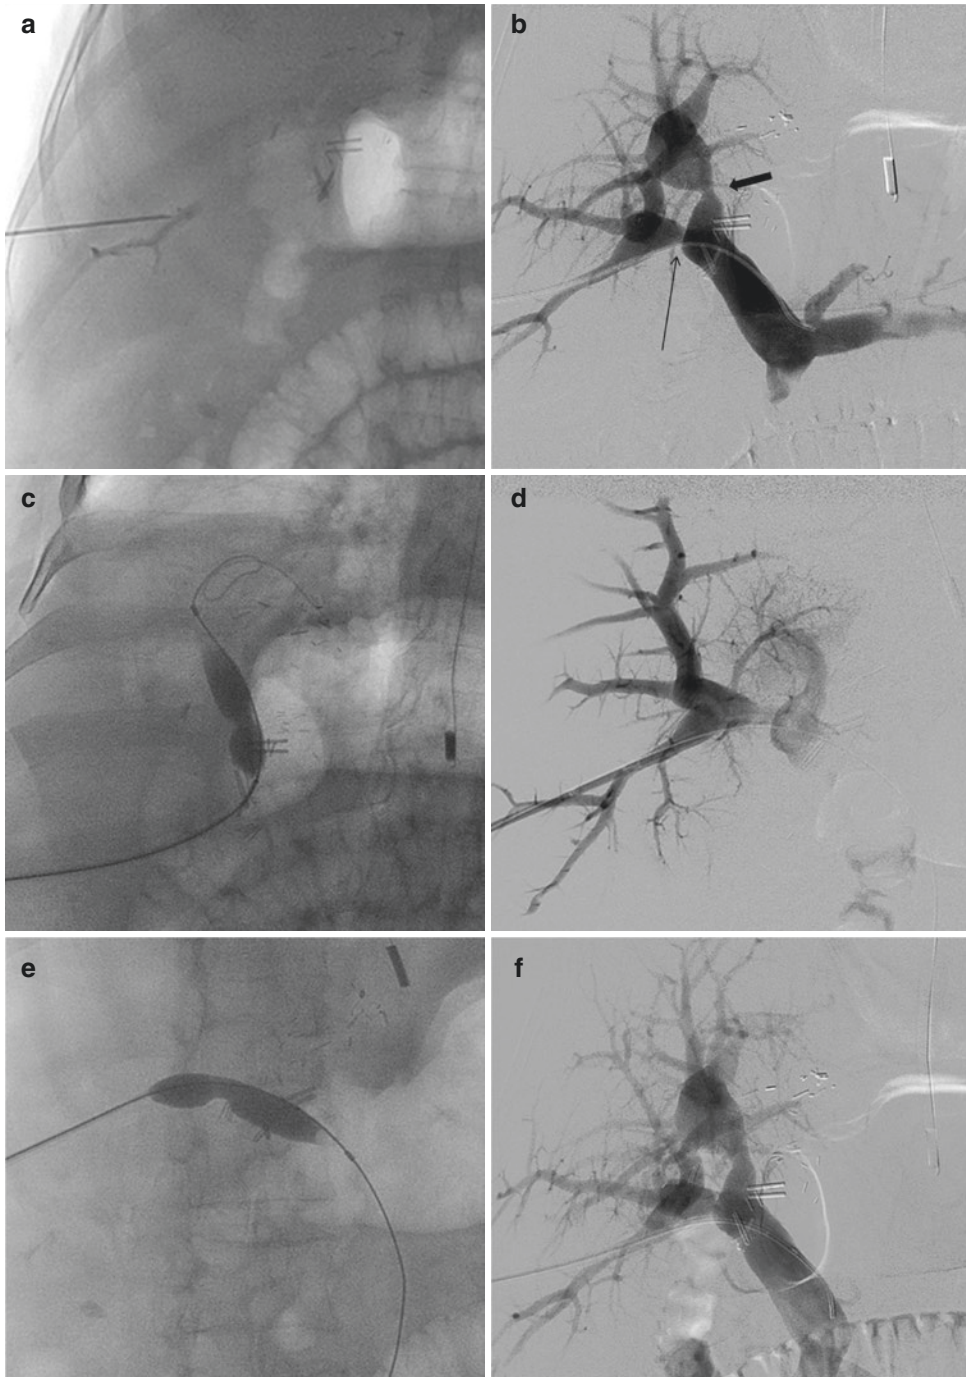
(a) Ultrasound-guided puncture taken in a branch of right posterior portal vein supplying Segment 6. Contrast runs through the needle in fluoroscopy shows opacification of the branch. (b) Portogram is taken by placement of diagnostic catheter in the right portal vein via the access secured through trans-hepatic route in Segment 6 branch of the right posterior portal vein. Note the sites of portal vein stenosis in right anterior (short thick arrow) and right posterior (long thin arrow) portal vein branches distal
